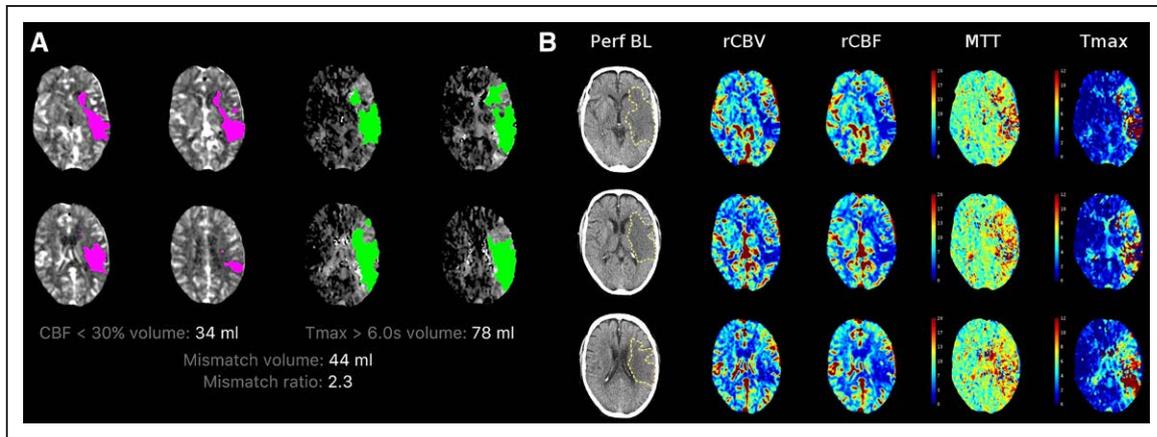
This 75-year-old man was last well 24 hours before presentation with a left middle cerebral artery (MCA) occlusion. His computed tomography (CT) perfusion mismatch map (A) demonstrates regions of severe reduction in cerebral blood flow (CBF) in the posterior MCA territory of 34 mL (shown in pink) and significant hypoperfusion of 78 mL (shown in green) resulting in a mismatch of 44 mL. B, shows the noncontrast CT scan coregistered to the perfusion images and demonstrates substantial volume of mild to moderate hypodensity in most of the MCA territory (yellow outline) representing a large subacute infarct. The CBF map demonstrates there has been substantial recruitment of leptomeningeal collaterals into the anterior region of infarct, which explains the underestimation of the ischemic core on the mismatch map. rCBV indicates relative cerebral blood volume.
